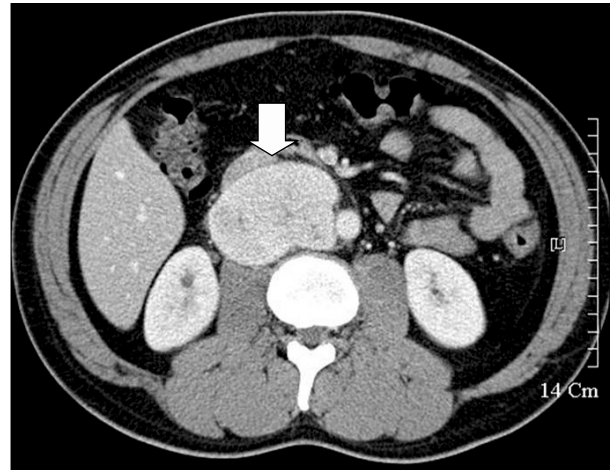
CT scan of the abdomen shows a well-defined enhancing mass (8x5 cm) with a non-homogenous, low density portion on the back of the vena cava at the level of renal hilum. The vena cava is pushed forward by the mass (white arrow).
